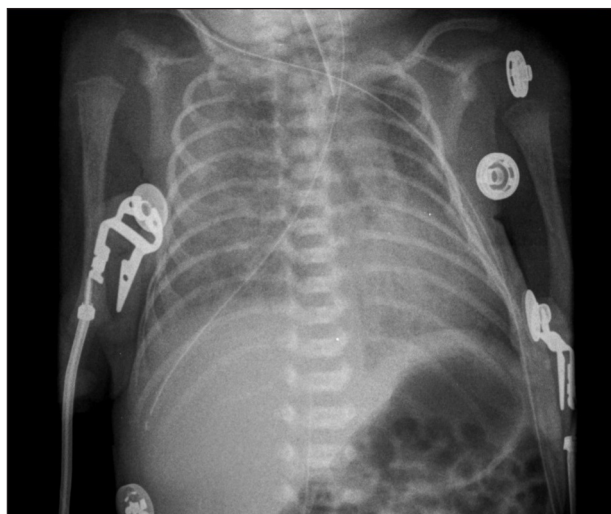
Chest radiograph revealing a feeding tube in the right pleural cavity, indicating a perforation of the thoracic esophagus.
